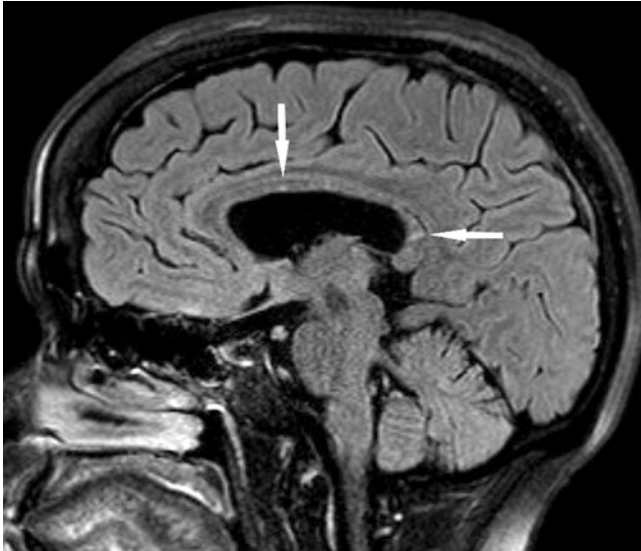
Sagittal FLAIR MRI with hyperintensities demonstrating characteristic “snowball” and “spoke” lesions of the corpus callosum in a patient with Susac's syndrome (Courtesy of Sumit Sharma, MD)
